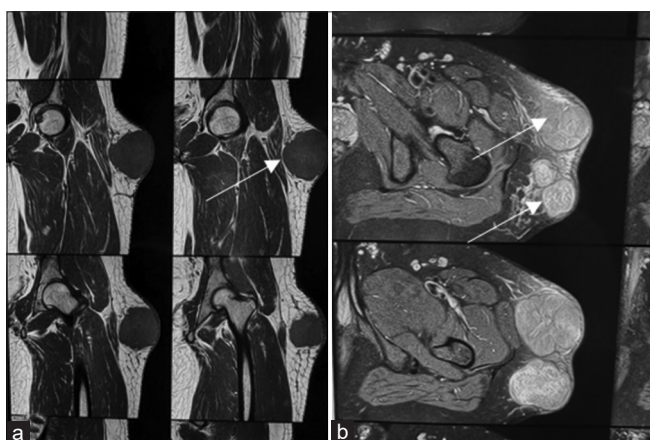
(a) Magnetic resonance imaging of left thigh detecting a heterogenous mass which is well above the muscle plane and in the subcutaneous tissue (b) Another section depicting a multilobulated heterogenous mass well above the adjustment muscle plane and fascia
